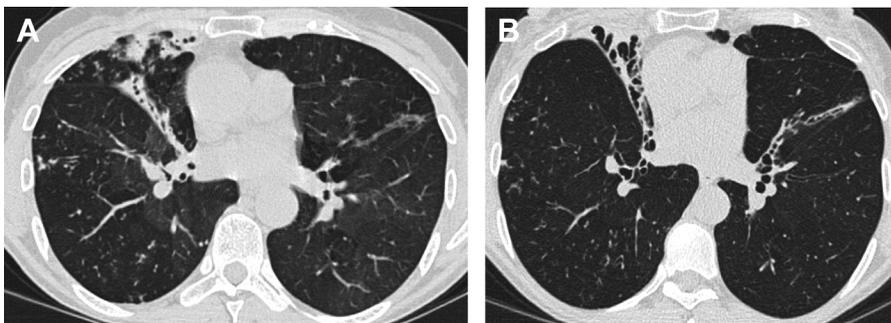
67-year-old woman with MAC. Axial CT images (A, B) show bronchiectasis in the right middle lobe and lingula with tree-in-bud nodules in the middle and lower lobes. Also, note mosaic attenuation indicative of air trapping.
